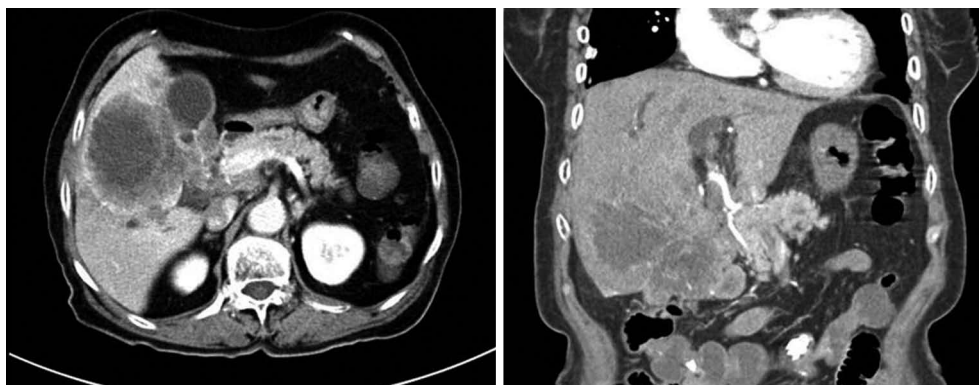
Findings of initial abdominal computed tomography. Computed tomography showed a large mass located in the liver, common hepatic duct, and common bile duct.
